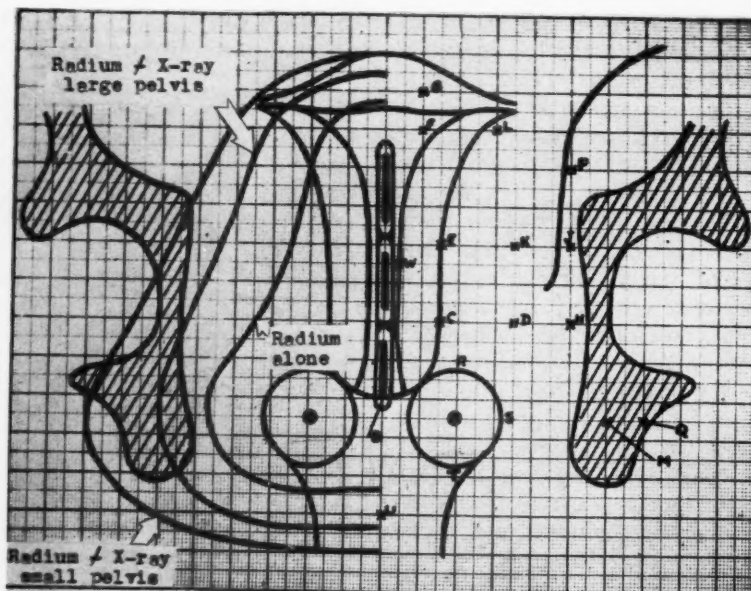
Isodose curves describing the approximate limits of a pelvic dose of 4,500 r given by 8,000 mg.-hr. of radium and its addition to the x-ray dose of 3,500 r to each of four pelvic portals in pelvis of varying diameters.
